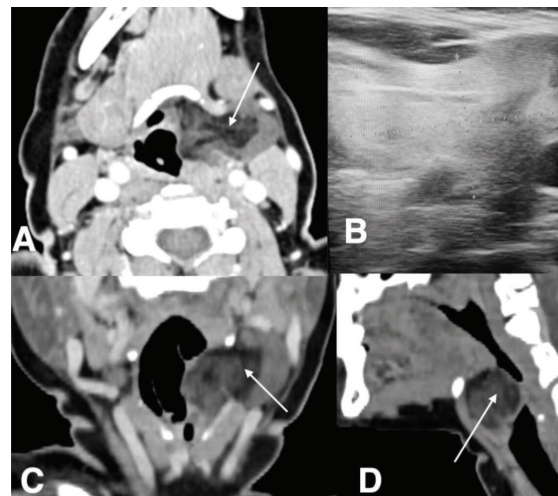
Axial contrast CT images (A, C and D) shows a well defined hypodense heterogenous fat containing lesion (white arrow) noted in the left infra hyoid region in the left paraglottic space abutting the left vocal cord medially and submandibular gland laterally. Axial USG image (B) showing hyper echoic lesion in the left infrahyoid region
